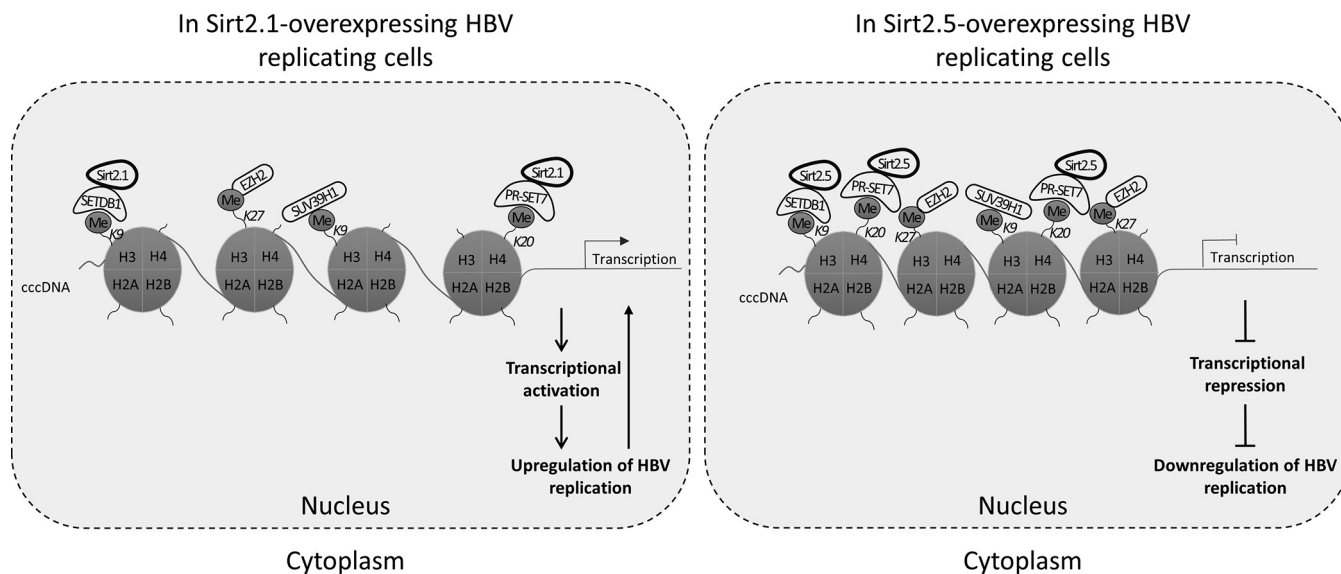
Sirt2.5 overexpression increases deposition of transcriptional repressive epigenetic markers on HBV cccDNA by repressive HKMTs. Repressive HKMTs, such as SETDB1, SUV39H1, PR-Set7, and EZH2, are recruited onto cccDNA in Sirt2.5-overexpressing cells to a greater extent than in Sirt2.1-overexpressing cells. H3K9me3 by SETDB1 and SUV39H1, H4K20me1 by PR-Set7, and H3K27me3 by EZH2 was more prominent in Sirt2.5-overexpressing cells than in Sirt2.1-overexpressing cells. Although both Sirt2.1 and Sirt2.5 interact with SETDB1 and PR-Set7 and can be recruited onto cccDNA, the Sirt2.5-SETDB1 and -PR-Set7 interactions are strengthened upon HBV replication, thereby inducing increased deposition of repressive markers in Sirt2.5-overexpressing cells. Although EZH2 and SUV39H1 cannot interact with either Sirt2.1 or Sirt2.5, more of them are recruited onto cccDNA, and deposition of repressive markers is increased in Sirt2.5-overexpressing cells. These repressive epigenetic modifications may silence cccDNA (closed state) and be transcriptionally inactive, thereby reducing viral replication.
